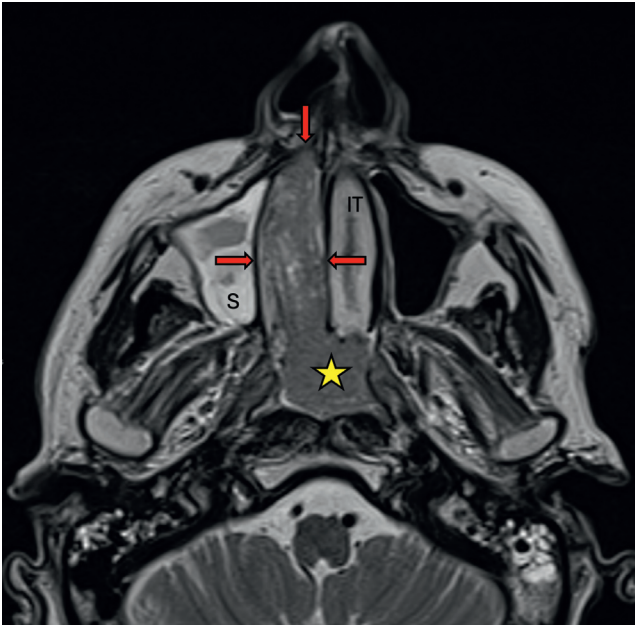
MRI of squamous cell carcinoma in the right nasal cavity. This T2-weighted axial sequence shows an intermediate signal mass (red arrows) filling the length of the right nasal cavity with a bulky component within the nasopharynx (yellow star). The lesion abuts but does not macroscopically infiltrate the medial maxillary antral wall laterally, the nasal septum medially, and the nasopharyngeal mucosa posteriorly. It is distinct from the normal contralateral inferior turbinate (IT) and retained maxillary antral secretions (S), both of which demonstrate high signal.
